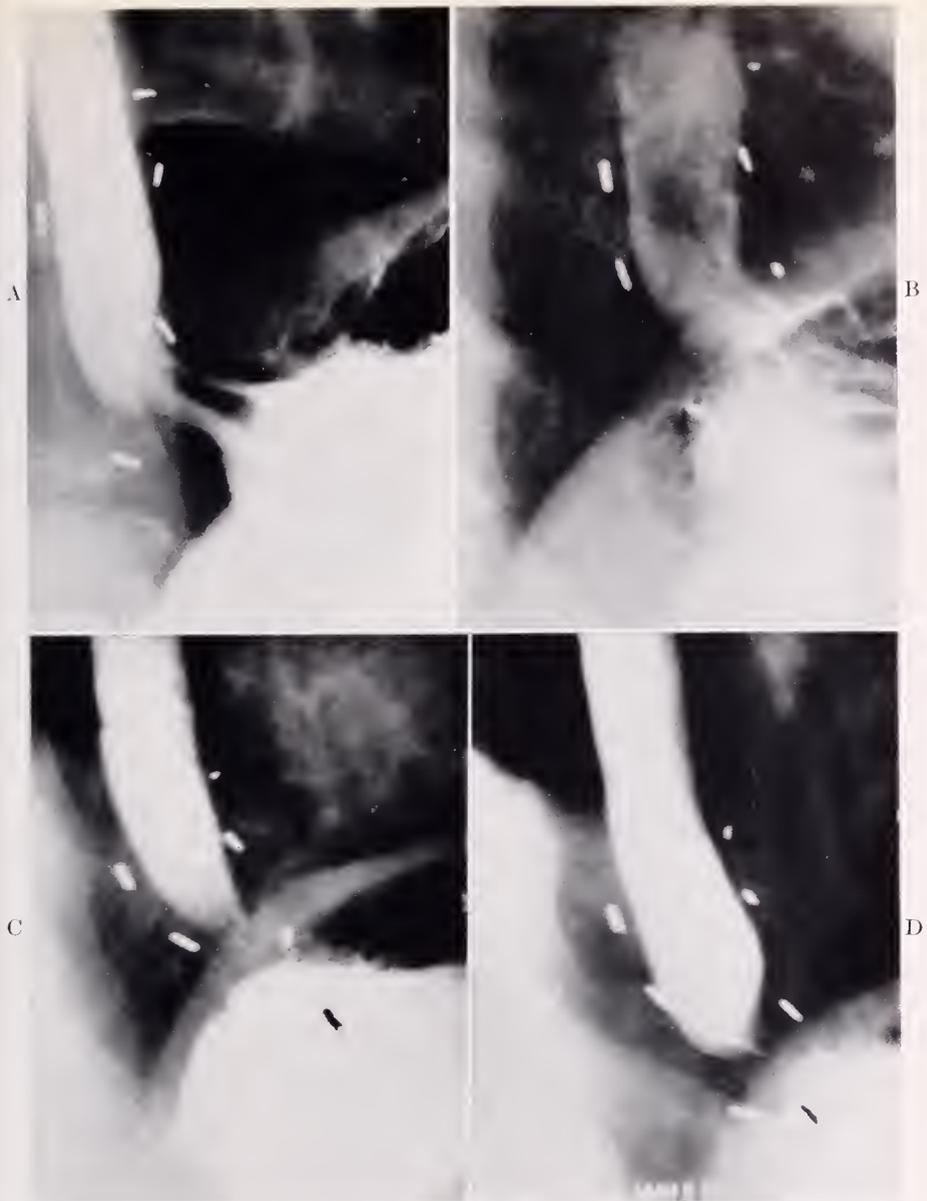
This patient, 26 years old, presented himself after a transthoracic vagotomy with three opaque clips on each side of the esophagus down to the hiatus.
